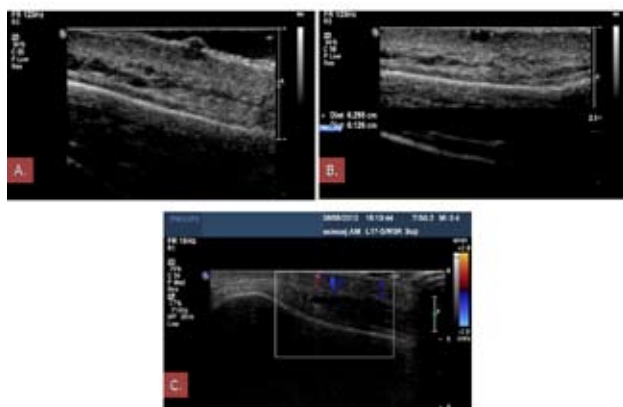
Case 1. US examinations. A. The well-delimited dermoepidermal lesion of reduced echogenicity, penetrating the dermoepidermal junction. B. Second US examination – the well-delimited hypoechoic lesion, 2.5x1.2mm in size. C. Color Doppler scan showing numerous vascular flow signals within and around the lesion.
